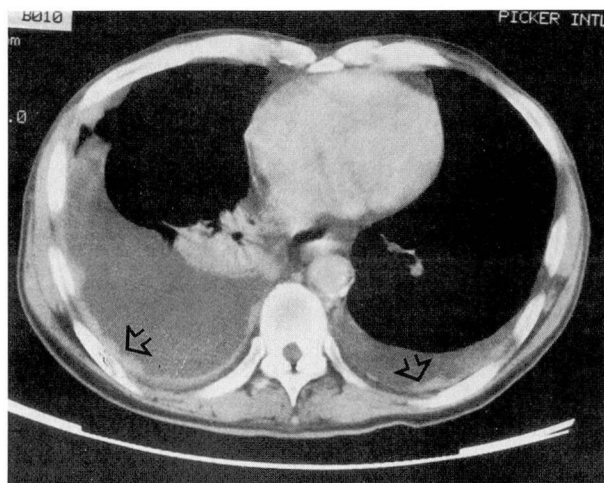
Thoracic computed tomographic scan showing irregularly thickened and contrast-enhanced pleura bilaterally (open arrows).
